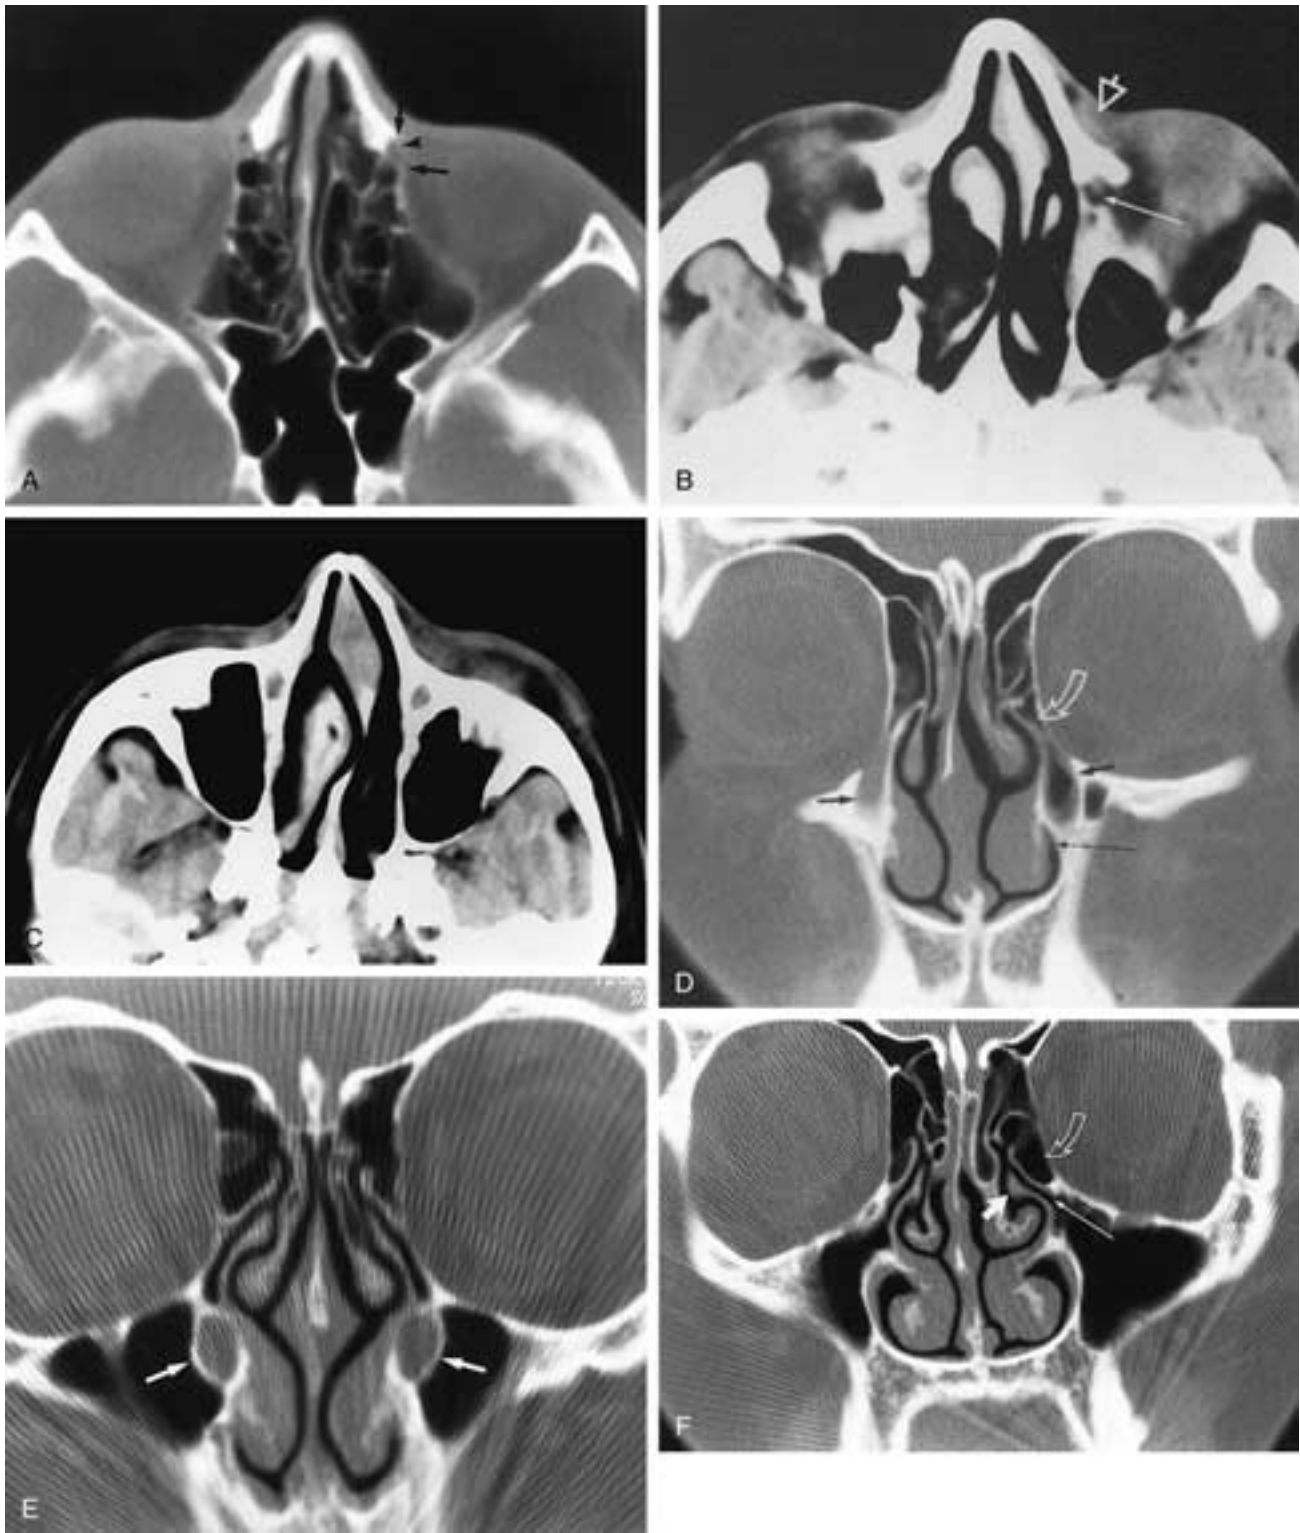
Normal CT anatomy. A to C, Axial. A, High-resolution axial CT scan shows the nasolacrimal fossa (*arrowhead*) and anterior and posterior lacrimal crests (*arrows*). B and C, Study done to assess preseptal lymphoma of the left orbit, noted as a soft-tissue density (*open arrow* in B) on both images. B, Fat-density tissue plane surrounding the lacrimal sac and proximal nasolacrimal duct (*thin arrow on the left*), which frequently is not identified (as in the nasolacrimal canal on the right) because of surrounding venous plexus, decreased fat content within the confined space, and artifact from adjacent bone. C, One slice, more inferiorly, is unable to define the nasolacrimal duct within the nasolacrimal canal. Compare this with the MR image of the nasolacrimal duct ([Fig. 10-26](#)). D to F, Coronal. D, Nasolacrimal canal (*short arrows*) is seen bilaterally lateral to the middle meatus and is directed inferiorly toward the inferior meatus (*thin arrow*). Note the normal cortical margin to the canal. Ethmoid bullae (*open arrow*) lie just medial to the superior aspect of the nasolacrimal canal. E, Nasolacrimal canals are oriented postinferiorly from superior to inferior. Depending on the angulation of coronal imaging, the canal may be obliquely transected (*arrows*). F, Just posterior to the nasolacrimal canal, a coronal image shows the osteomeatal unit. Ethmoid bulla (*open arrow*), infundibulum (*thin arrow*), and uncinate process (*short arrow*) are seen.
